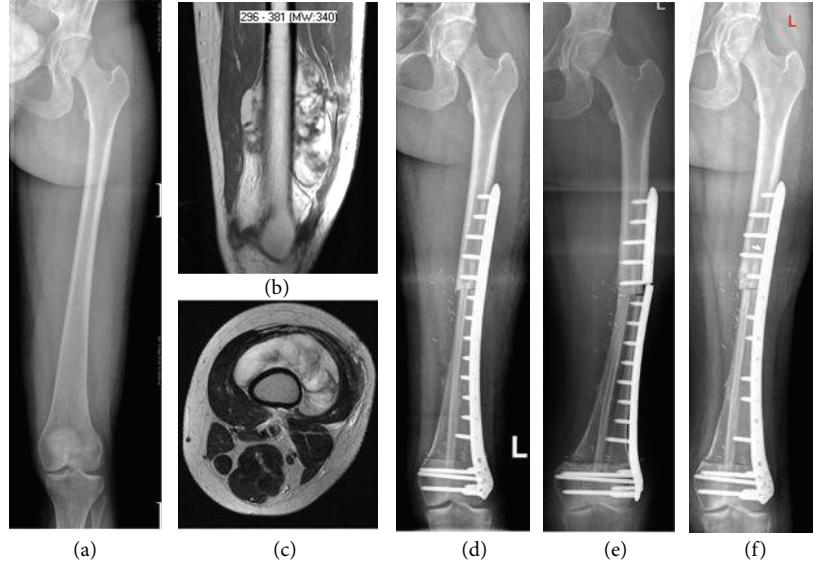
X-ray and MRI imaging in a 31-year-old female patient with Liposarcoma grade 2 of the left femur: before operation (a)-(b), one week after operation (c), plate breakage and fracture 15 months after operation (d), and one month after revision (e).
